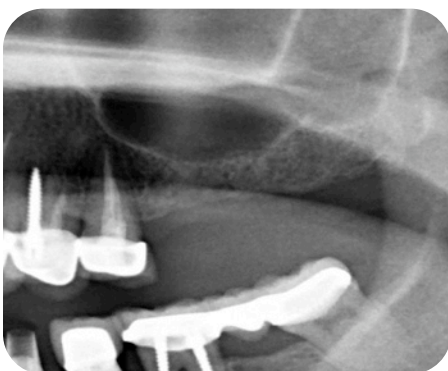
preoperative radiograph showing only 4-6 mm of residual bone height.
